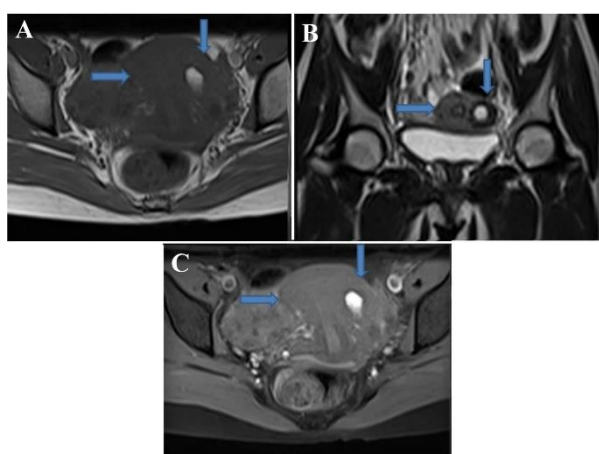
MRI images: (A) axial T1-weighted image shows uterus (horizontal arrow) and hyperintense cavity of ACUM (vertical arrow) suggestive of blood products, (B) coronal T2-weighted image shows uterus (horizontal arrow) and ACUM (vertical arrow) with a hyperintense signal in accessory cavity, and (C) axial post-contrast T1 fat-saturated image shows normal enhancement of uterine myometrium (horizontal arrow) and normally enhancing myometrium surrounding cavity of ACUM (vertical arrow)
